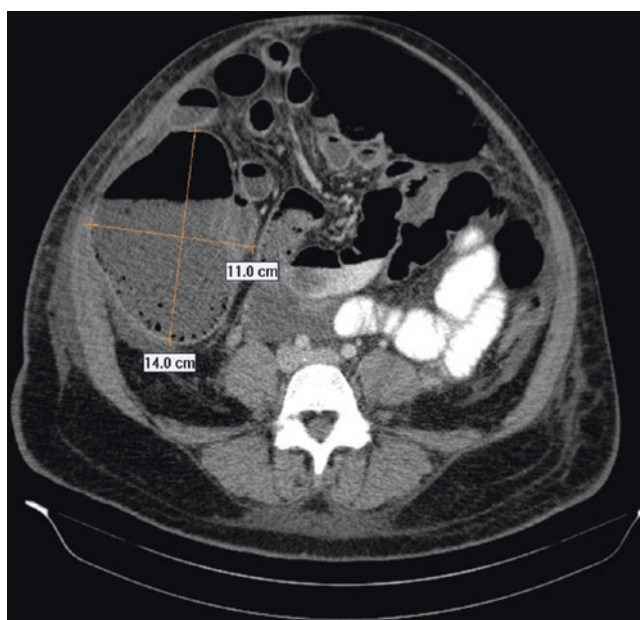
Axial CT scan image measuring the cecal dimensions in the setting of acute colonic pseudo-obstruction. (Courtesy of Daniel L. Feingold, MD)
